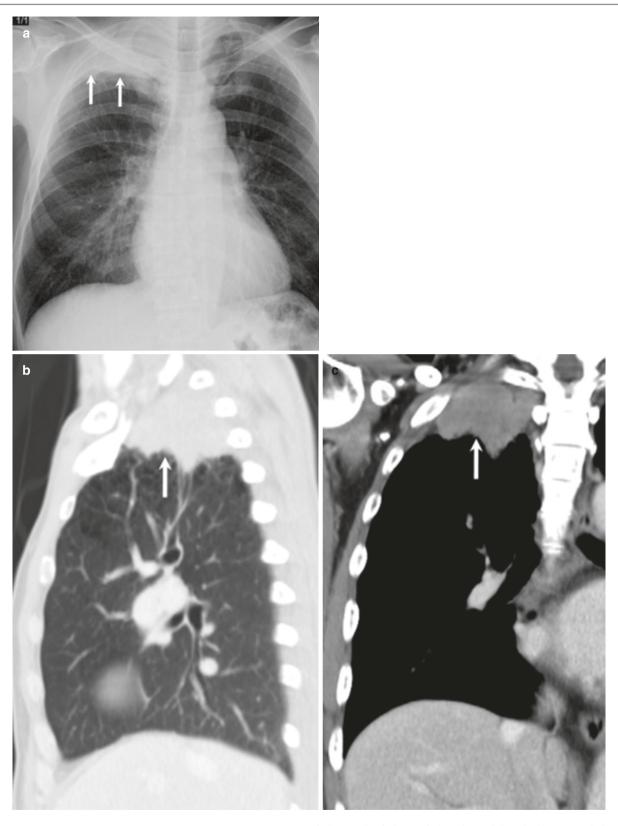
A 71-year-old man with Pancoast tumor. (a) Frontal radiograph of chest shows asymmetric right apical pleural thickening (arrow). (b, c) Sagittal and contrast-enhanced coronal CT thorax image
